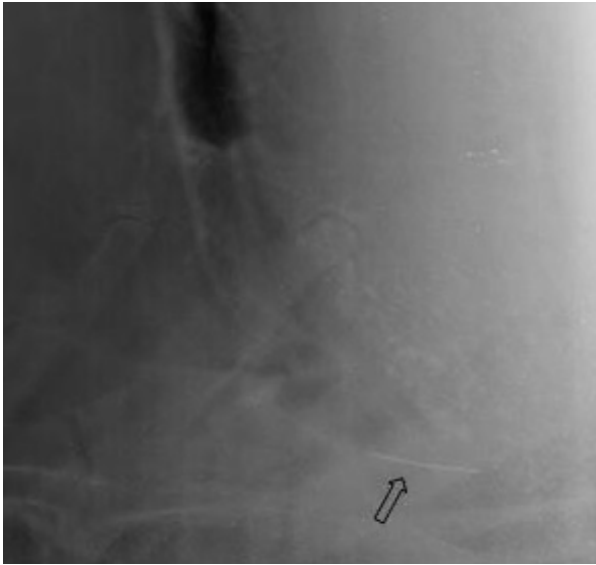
Lateral radiograph showing linear metallic foreign body opacity in the sternal region (black arrow), present outside the reticulum.
